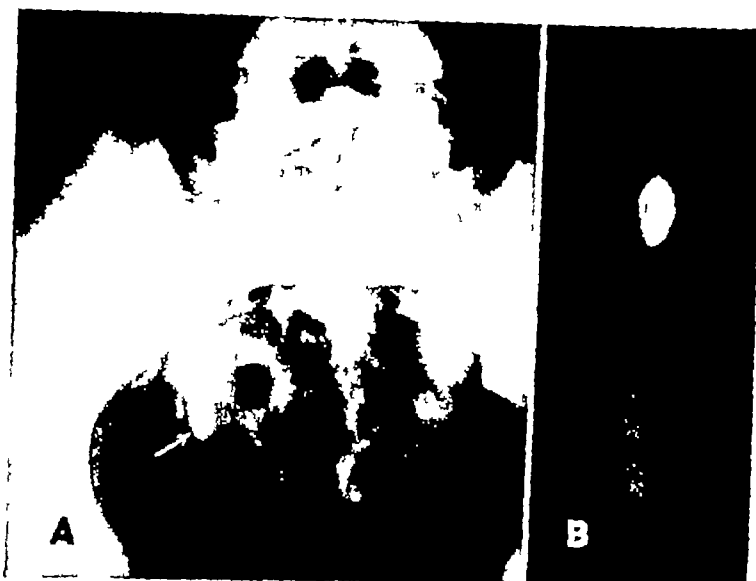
Case 7 A Anteroposterior view of the pelvis shows a laminated calculus (arrow) in the line of the right lower ureter. An intravenous pyelogram showed the calculus medial to the ureter. B Roentgenogram of the appendix after removal showing the calculus in the proximal third of the slightly swollen organ. No perforation.
